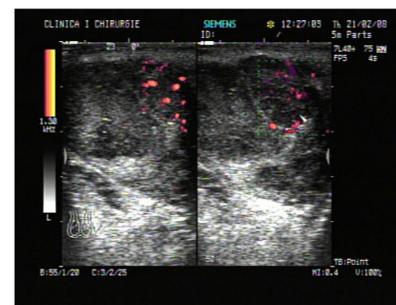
Ultrasound of testes at diagnosis
